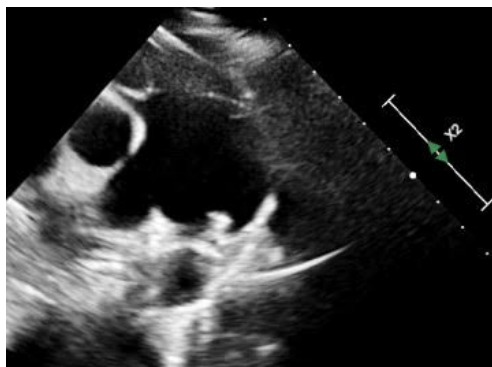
Post-procedure 2D echocardiography showing the PDA device in place.
